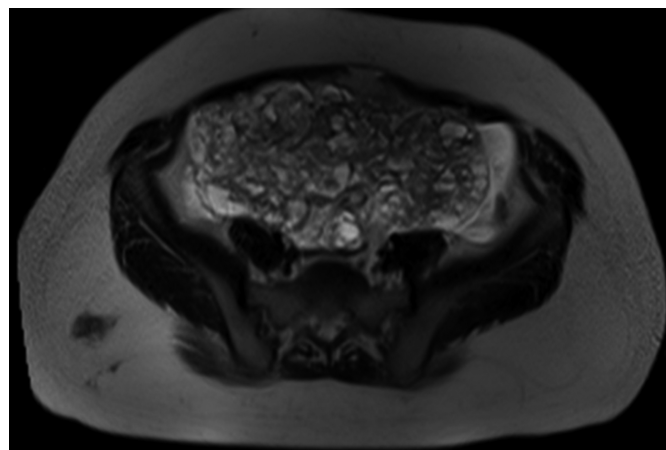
MRI showing the pelvic mass before initiation of chemotherapy.
